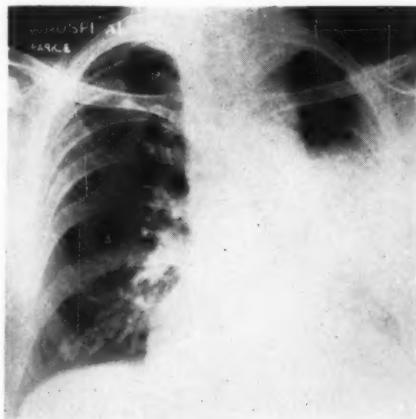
P.A. X-ray of chest showing collapse of left lower lobe and lingula.
